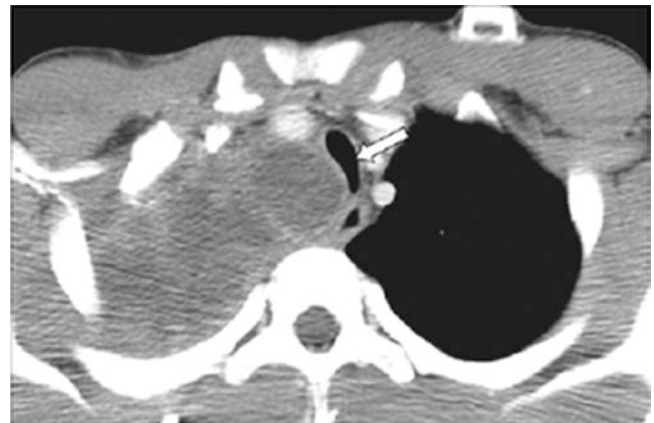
A 14-year-old boy who presented with known metastatic prostate rhabdomyosarcoma. Enhanced axial CT image shows a large heterogeneously enhancing middle mediastinal mass causing tracheal narrowing (arrow)
